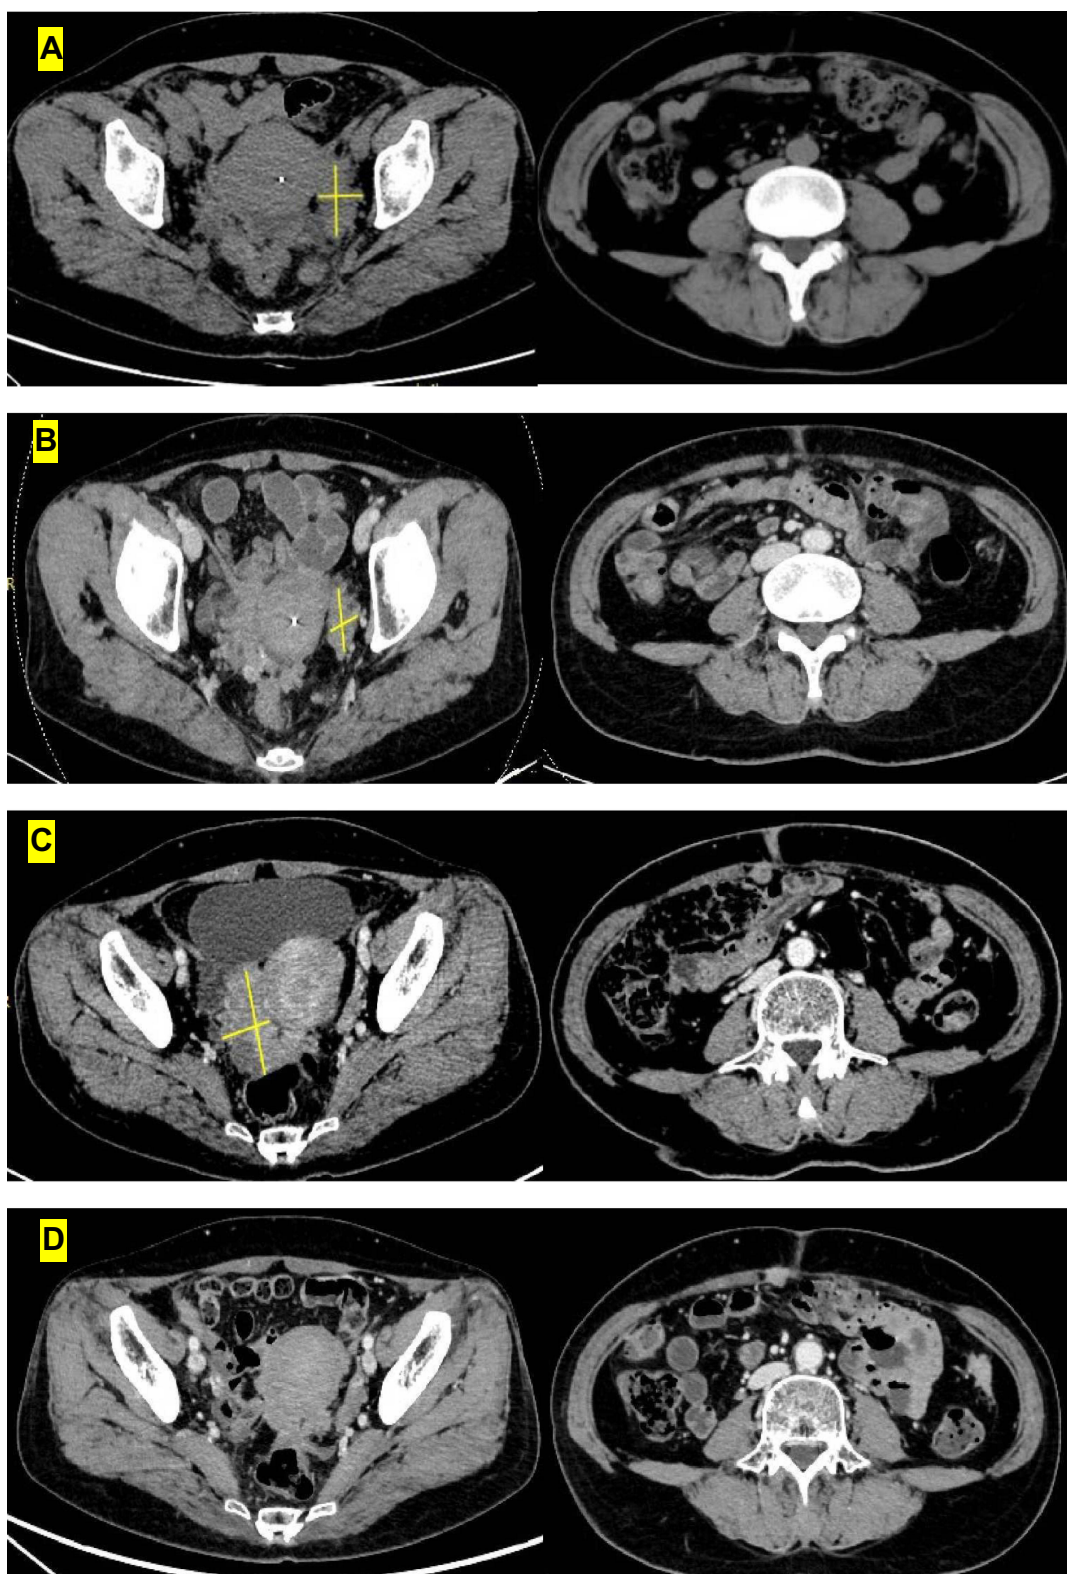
Changes on CT scans during treatment.
